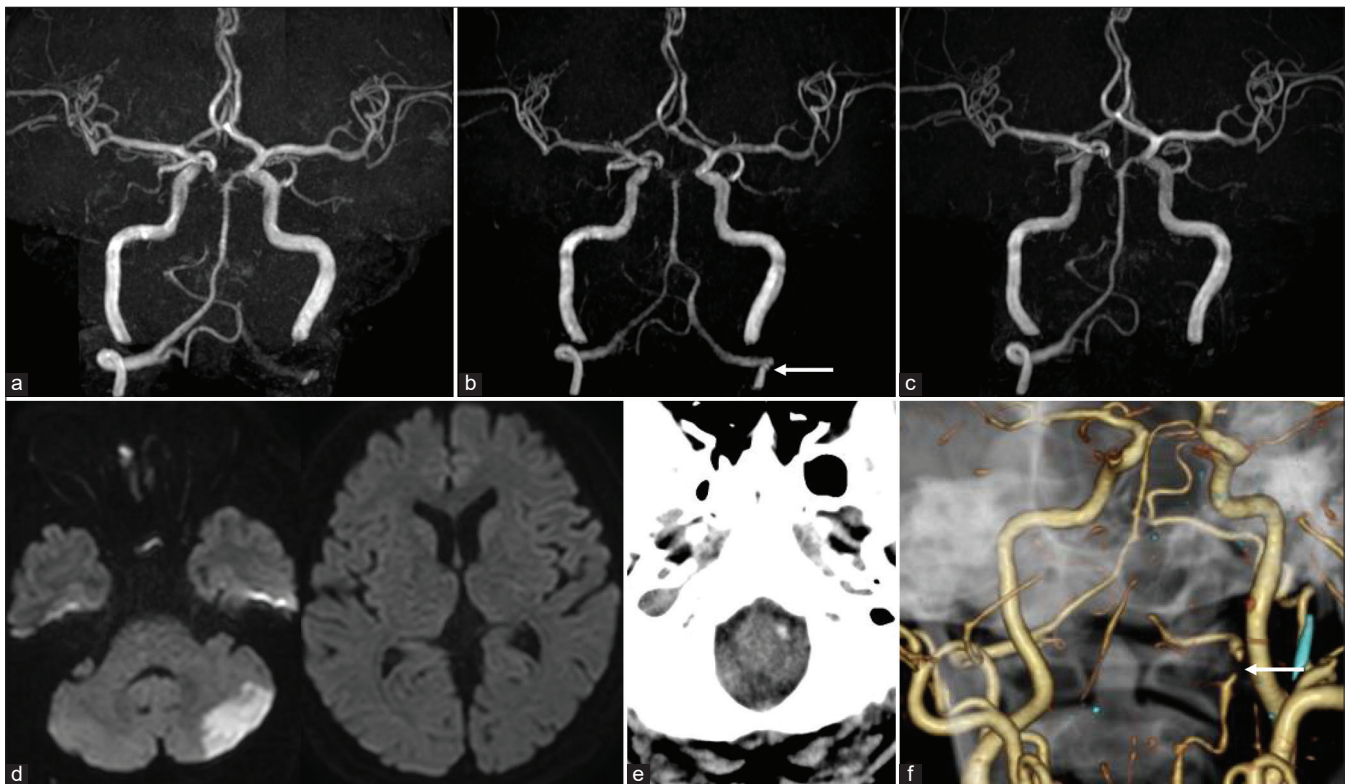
Imaging findings at first and second hospitalizations. Magnetic resonance angiography on day 2 showing spontaneous recanalization of the left vertebral artery (a). Magnetic resonance angiography on day 6 showing further increased blood flow signal in the left vertebral artery and vessel wall irregularity of the left vertebral artery at the level of the left foramen transversum of Atlas. White arrow indicates vessel wall irregularity (b). Magnetic resonance angiography on day 20 showing occlusion of the left vertebral artery (c). Diffusion-weighted magnetic resonance imaging on day 20 showing acute cerebral infarction in the left posterior inferior cerebellar artery territory (d). Computed tomography (CT) of the head on day 20 showing a high density area in the left vertebral artery V4 segment (e). CT angiography on day 20 showing severe stenosis of the left vertebral artery at the level of the foramen transversum of Atlas, with no visualization of the left posterior inferior cerebellar artery. White arrow indicates severe stenosis of the left vertebral artery (f).
